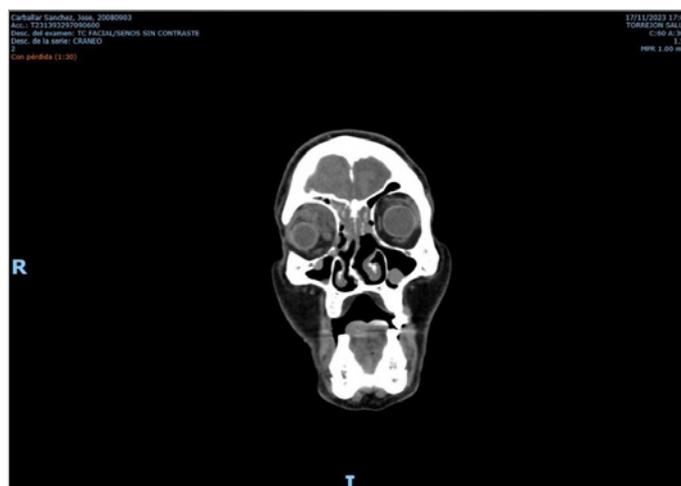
Coronal CT scan.
